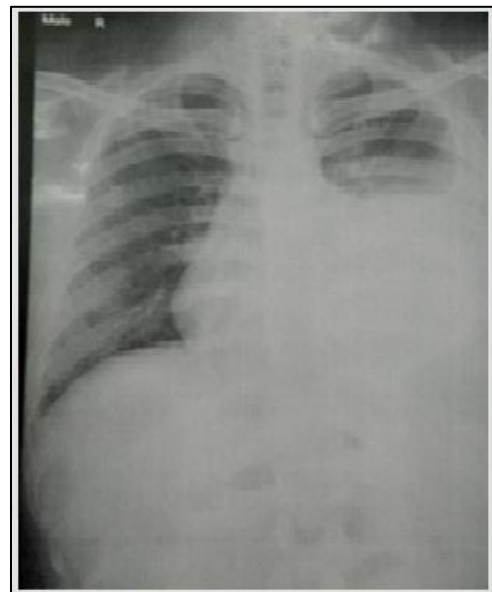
Chest radiograph reveals massive left-sided pleural effusion
